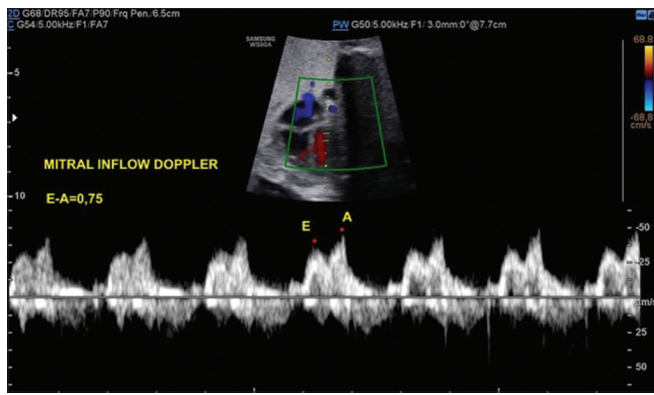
Doppler tracing of mitral inflow obtained at four-chamber view showing normal pattern of left ventricle diastolic filling with E/A ratio <1.0. The sample volume of the pulsed Doppler (2–3 mm) is positioned in the left ventricle immediately distal to the mitral valve at an insonation angle smaller than 20°. LV: Left ventricle, LA: Left atrium, RV: Right ventricle, RA: Right atrium, M: Mitral valve flow, E: E-wave (passive ventricular filling), A: A-wave (atrial contraction)
